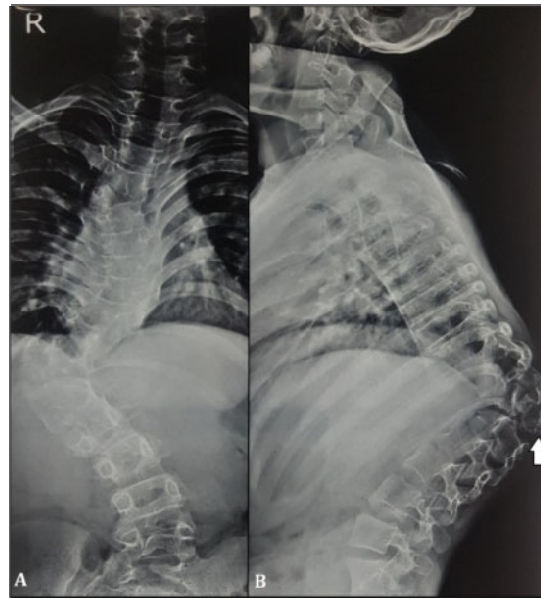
Preoperative radiograph anteroposterior view (A) and lateral view (B) of spine showing gross kyphoscoliotic deformity with right sided convexity and D12 hemivertebra (white arrow).
